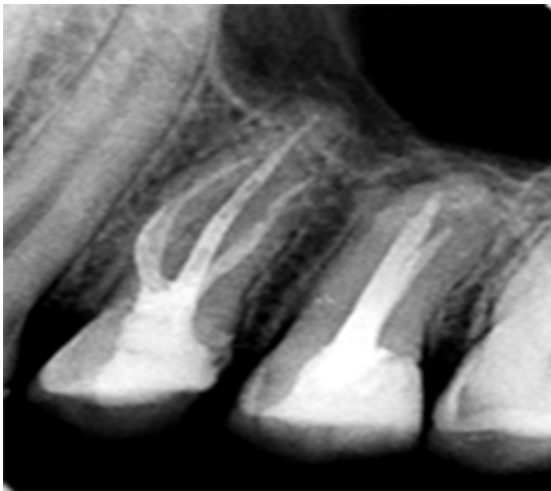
Periapical radiograph following the obturation of the three root canals.
